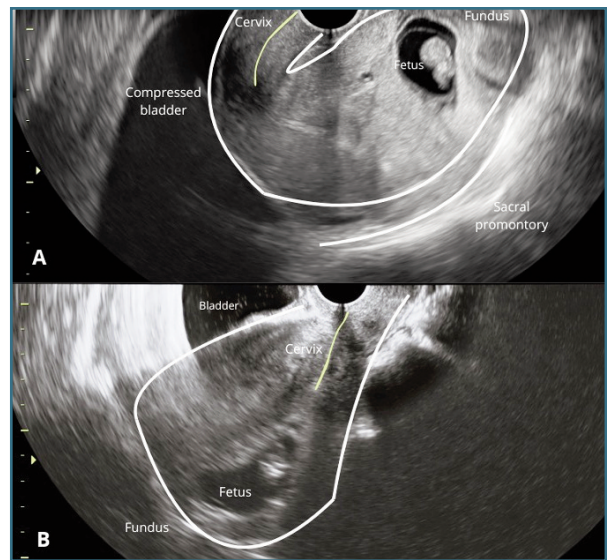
Sonographic findings in early gestational uterine incarceration (IGU) and after successful reduction. (A) Transvaginal ultrasound showing a retroverted gravid uterus with a markedly elongated, anteriorly displaced cervix (yellow line) compressing the bladder, and the uterine fundus trapped against the sacral promontory; a viable intrauterine pregnancy is present. (B) Post-ultrasound-guided manual reduction demonstrating restoration of uterine anteversion, normal cervical position, and bladder decompression.
